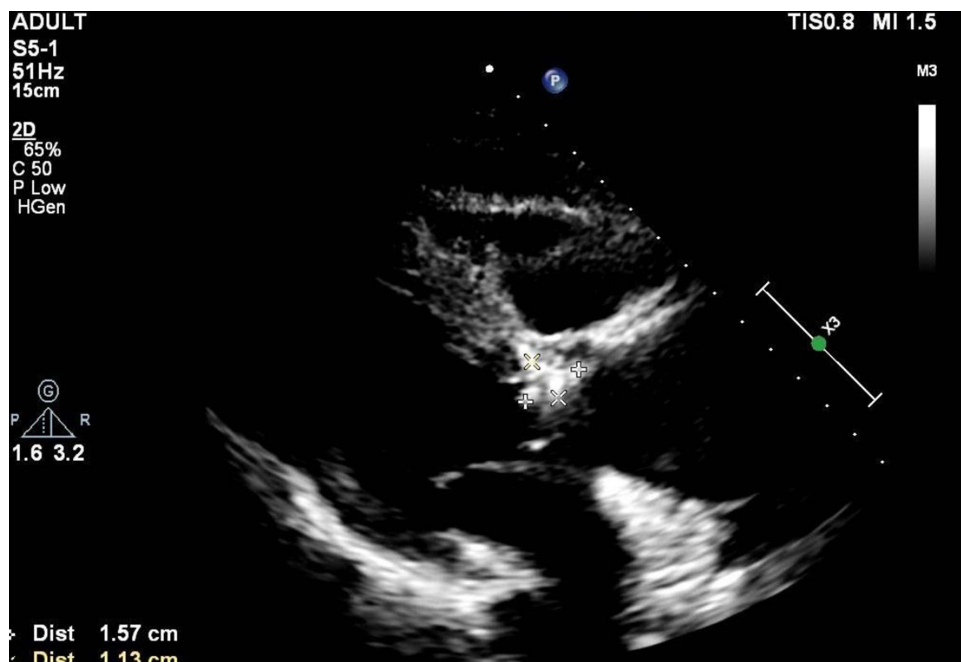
The results of transesophageal echocardiography.
